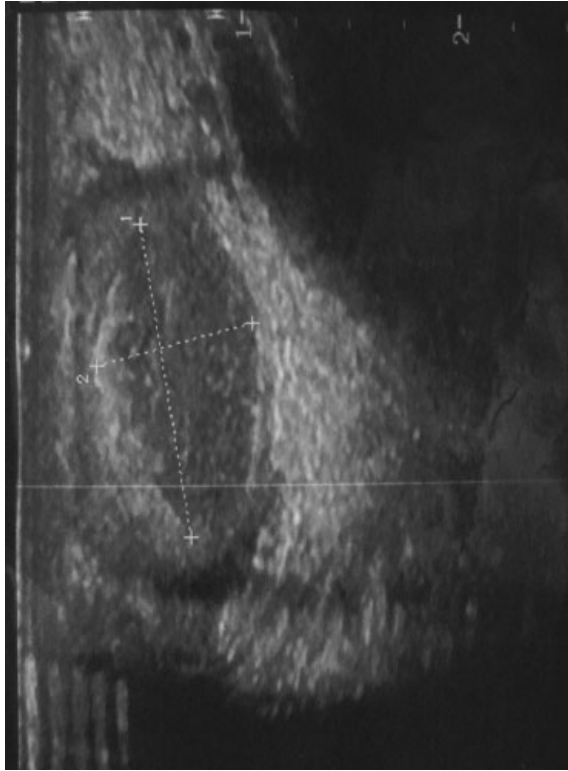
Ultrasound image before surgery. Well-defined, oval, slightly heterogeneous, hypoechoic tumor with a partial surrounding hyperechoic halo is observed in the left testis.
